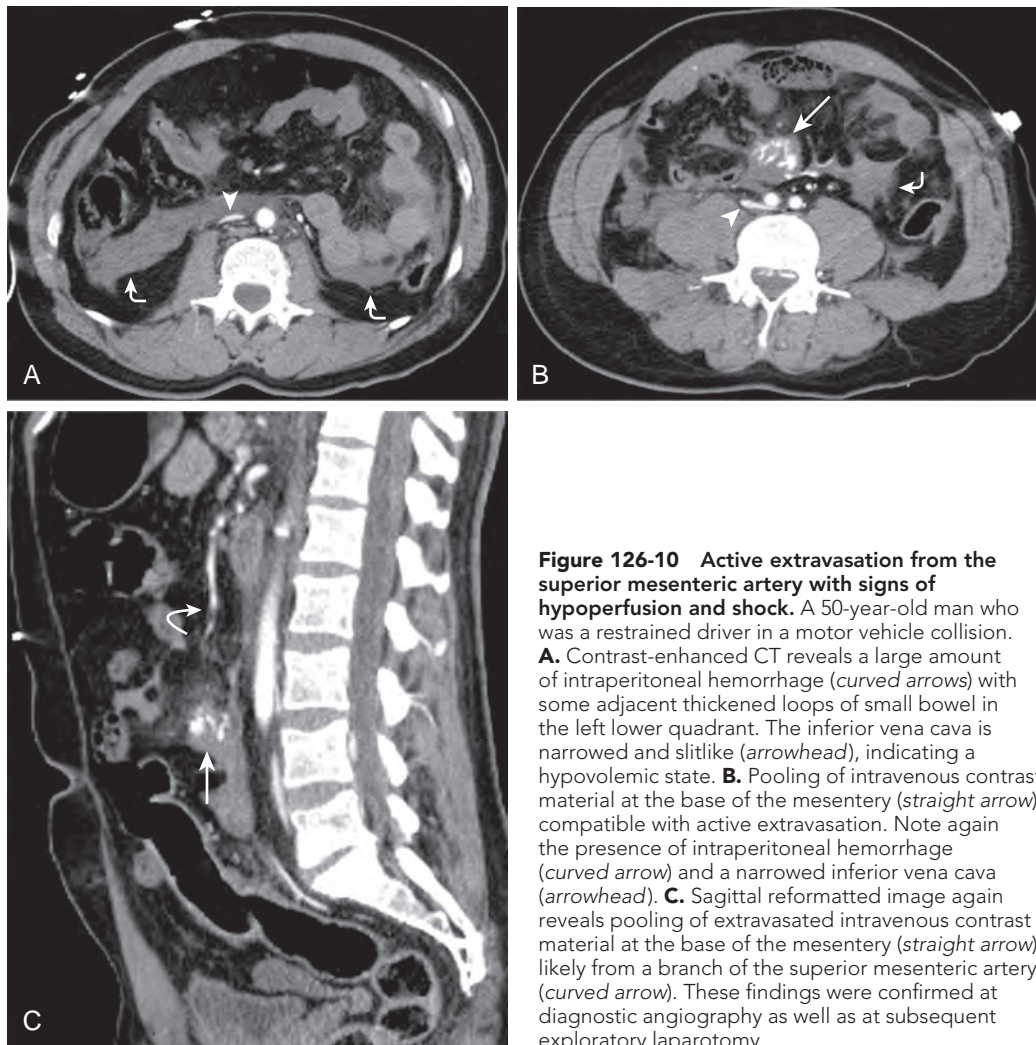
Active extravasation from the superior mesenteric artery with signs of hypoperfusion and shock. A 50-year-old man who was a restrained driver in a motor vehicle collision. A. Contrast-enhanced CT reveals a large amount of intraperitoneal hemorrhage (*curved arrows*) with some adjacent thickened loops of small bowel in the left lower quadrant. The inferior vena cava is narrowed and slitlike (*arrowhead*), indicating a hypovolemic state. B. Pooling of intravenous contrast material at the base of the mesentery (*straight arrow*), compatible with active extravasation. Note again the presence of intraperitoneal hemorrhage (*curved arrow*) and a narrowed inferior vena cava (*arrowhead*). C. Sagittal reformatted image again reveals pooling of extravasated intravenous contrast material at the base of the mesentery (*straight arrow*), likely from a branch of the superior mesenteric artery (*curved arrow*). These findings were confirmed at diagnostic angiography as well as at subsequent exploratory laparotomy.
